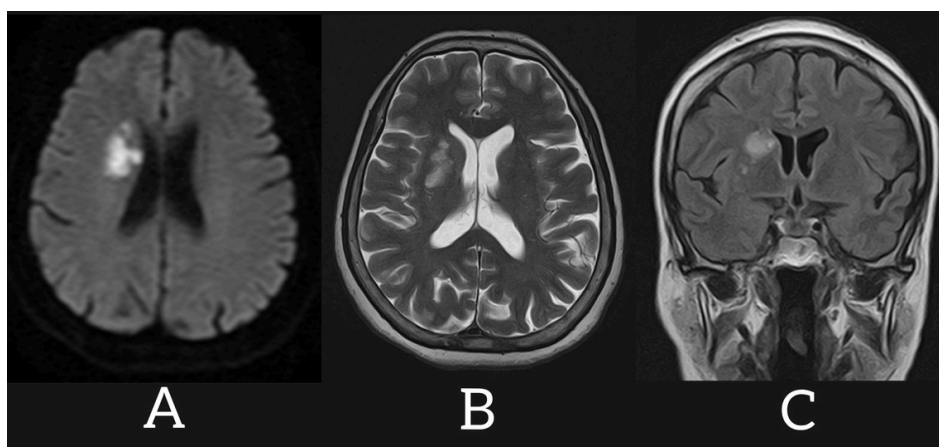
Non-contrast magnetic resonance image of the brain after 48 hours of the index event showing acute infarction of the right-side basal ganglia, A; Diffusion weighted image, B; Apparent diffusion coefficient image, C; T2 Flair images taken on admission(left) and after treatment(right) showed remarkable improvement
